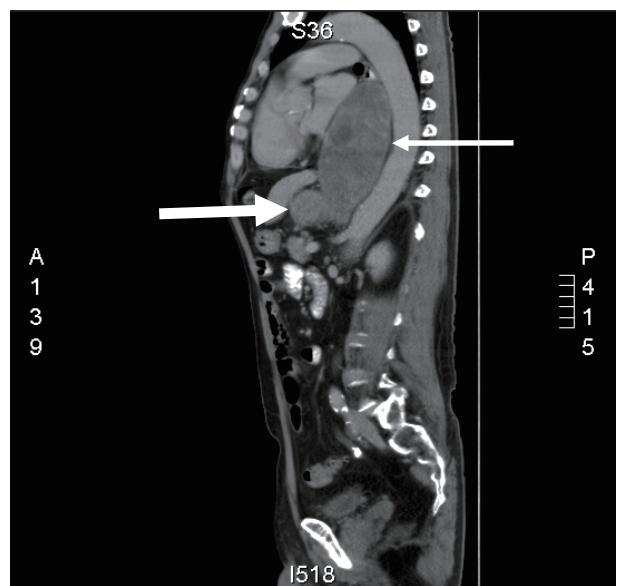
CT scan (sagittal view) with contrast revealed a large fusiform mass in the posterior aspect of the distal esophagus (thin arrow) and cardia of the stomach (thick arrow).
